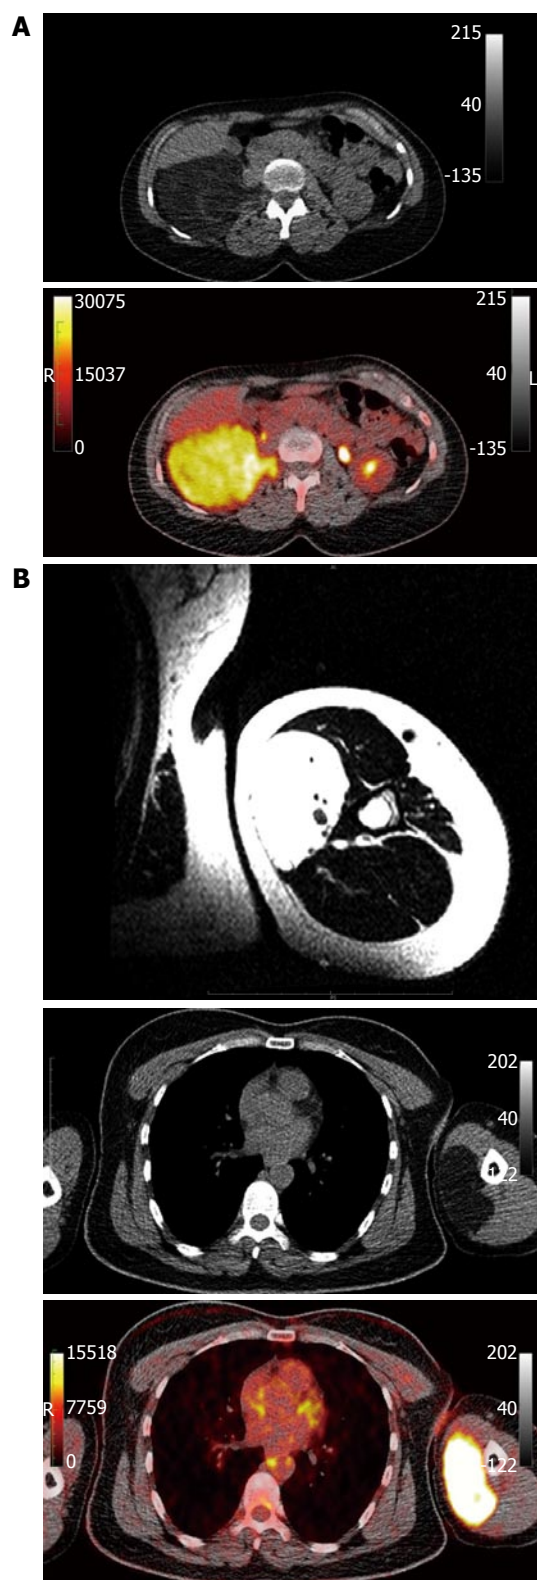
Computed tomography and magnetic resonance imaging. A: Computed tomography (upper row) and fused positron emission tomography/CT (PET/CT) (lower row) images of the retroperitoneal tumor; B: Magnetic resonance imaging (upper row), CT (middle row) and fused positron emission tomography/CT (PET/CT) (lower row) images of the tumor located in the left upper arm. Magnetic resonance imaging demonstrates a well-circumscribed mass without infiltration of the surrounding tissues. CT reveals a fat-equivalent mass, while PET/CT demonstrates intense fluorodeoxyglucose accumulation in the tumor area. CT: Computed tomography.
